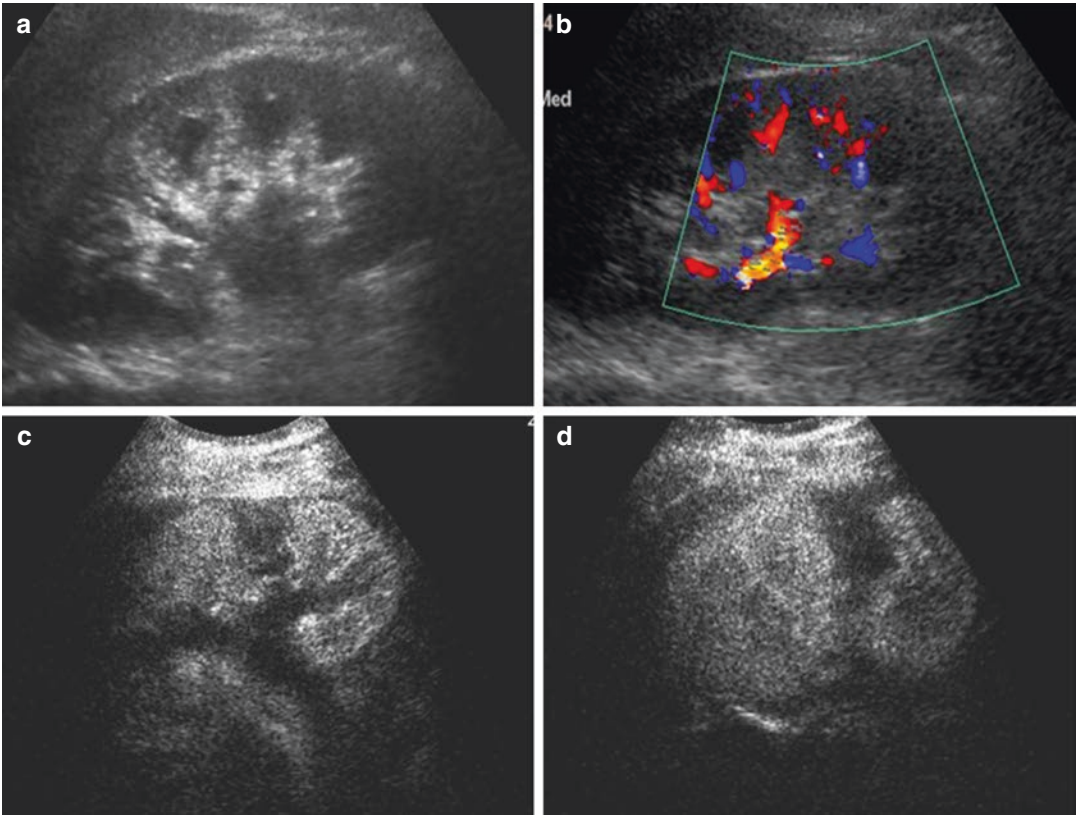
Baseline US examination (a) is inadequate to detect renal laceration because it is slightly hypo-isoechoic to the surrounding parenchyma. Color Doppler (b) shows a relative homogeneous perfusion. After contrast injection, CEUS demonstrates a large filling defect due to deep parenchymal laceration (c, d)
